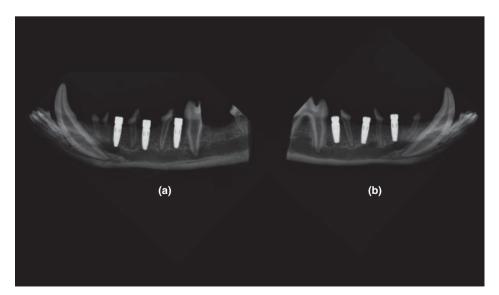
(a) Digital radiographs of Vitamin D C1 dopped implants after 12 weeks of healing, (b) Digital radiographs of SLA C1 implants after 12 weeks of healing.
